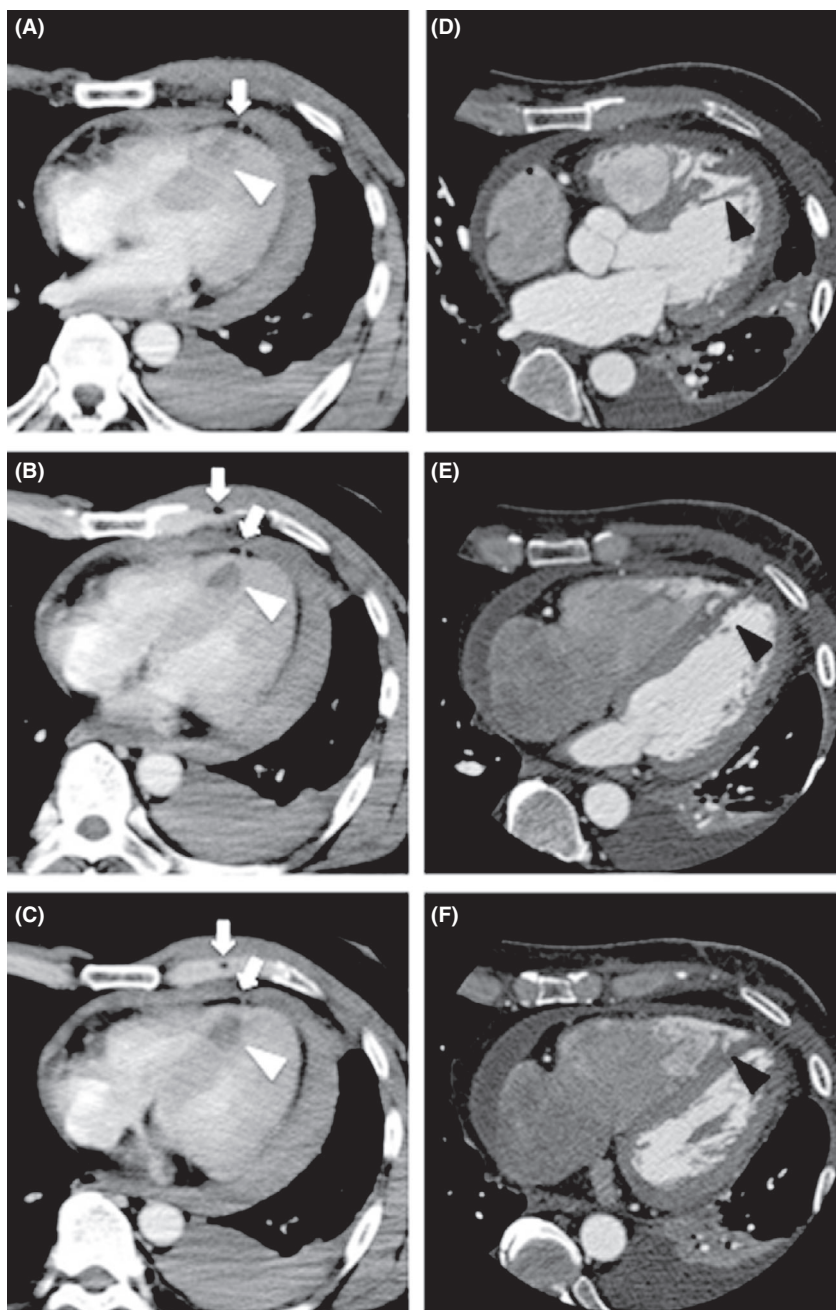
A–C, Initial contrast computed tomography of a 60-year-old man with a self-inflicted knife injury to the chest reveals the extent of a low attenuation lesion (hematoma; white arrowhead) at the muscular part of the interventricular septum. The pathway of the knife is recognized in the right ventricle from the chest wall (white arrows). Hematoma (white arrowhead) of the muscular part of the interventricular septum is on the extension line. D–F, Follow-up contrast computed tomography shows the traumatic ventricular septum perforation at the right ventricular mid-anteroseptal wall (black arrowhead).
